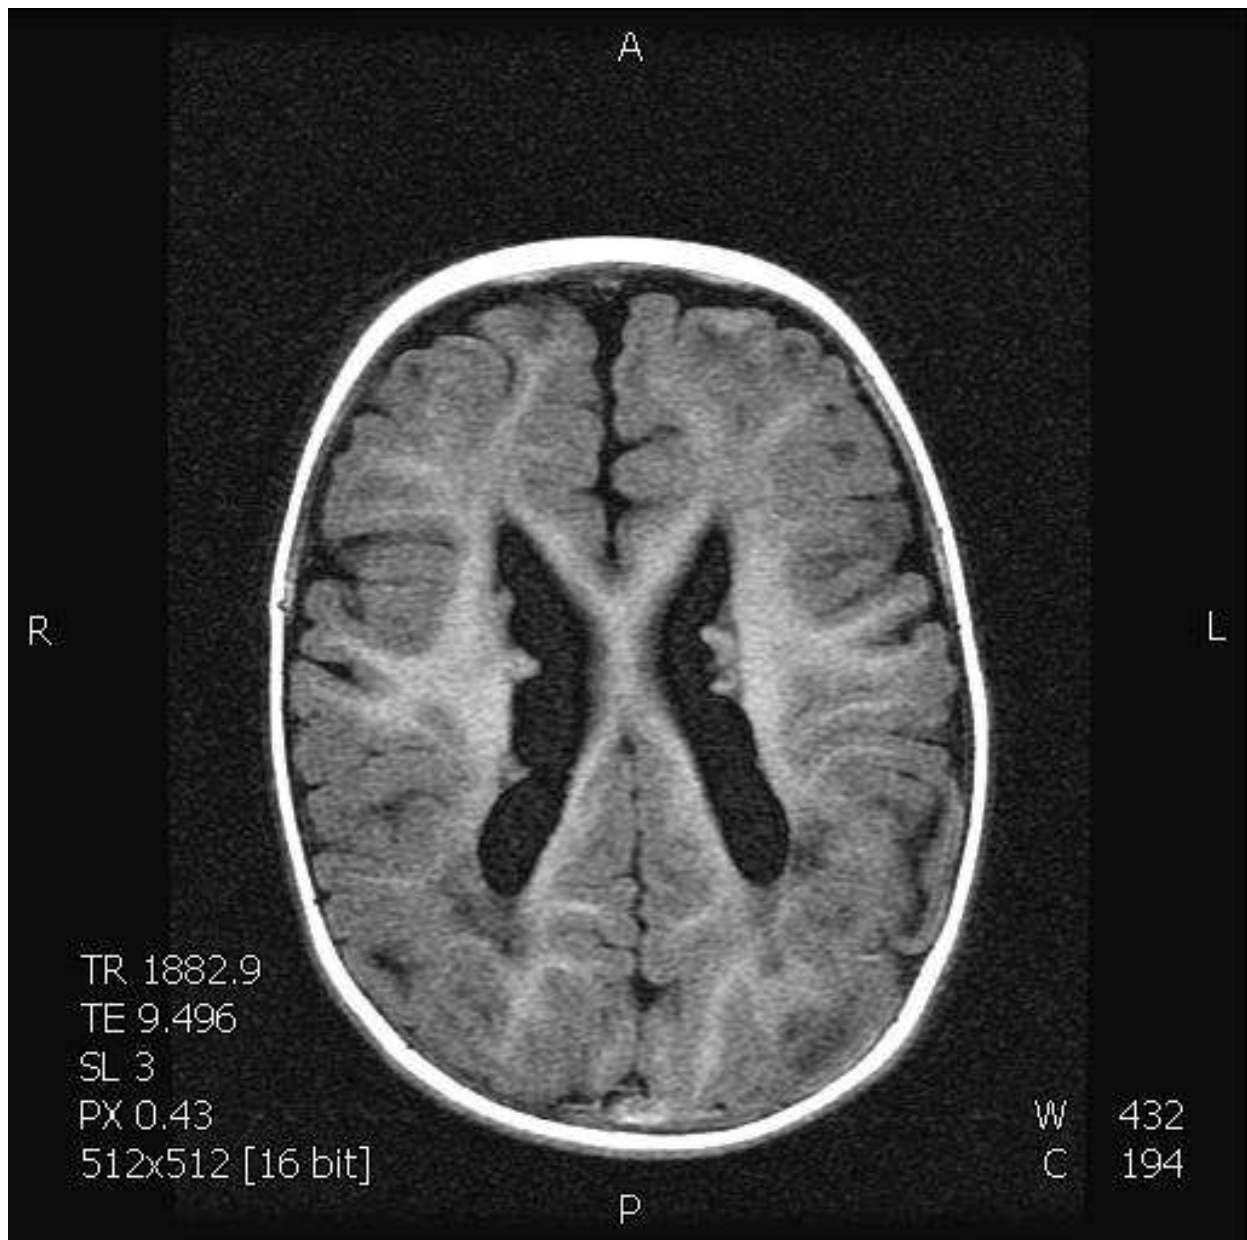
Neurocysticercosis: T1-weighted SE images (gadolinium-enhanced) shows small cystic intraparenchymal lesions and peripheral enhancement.
